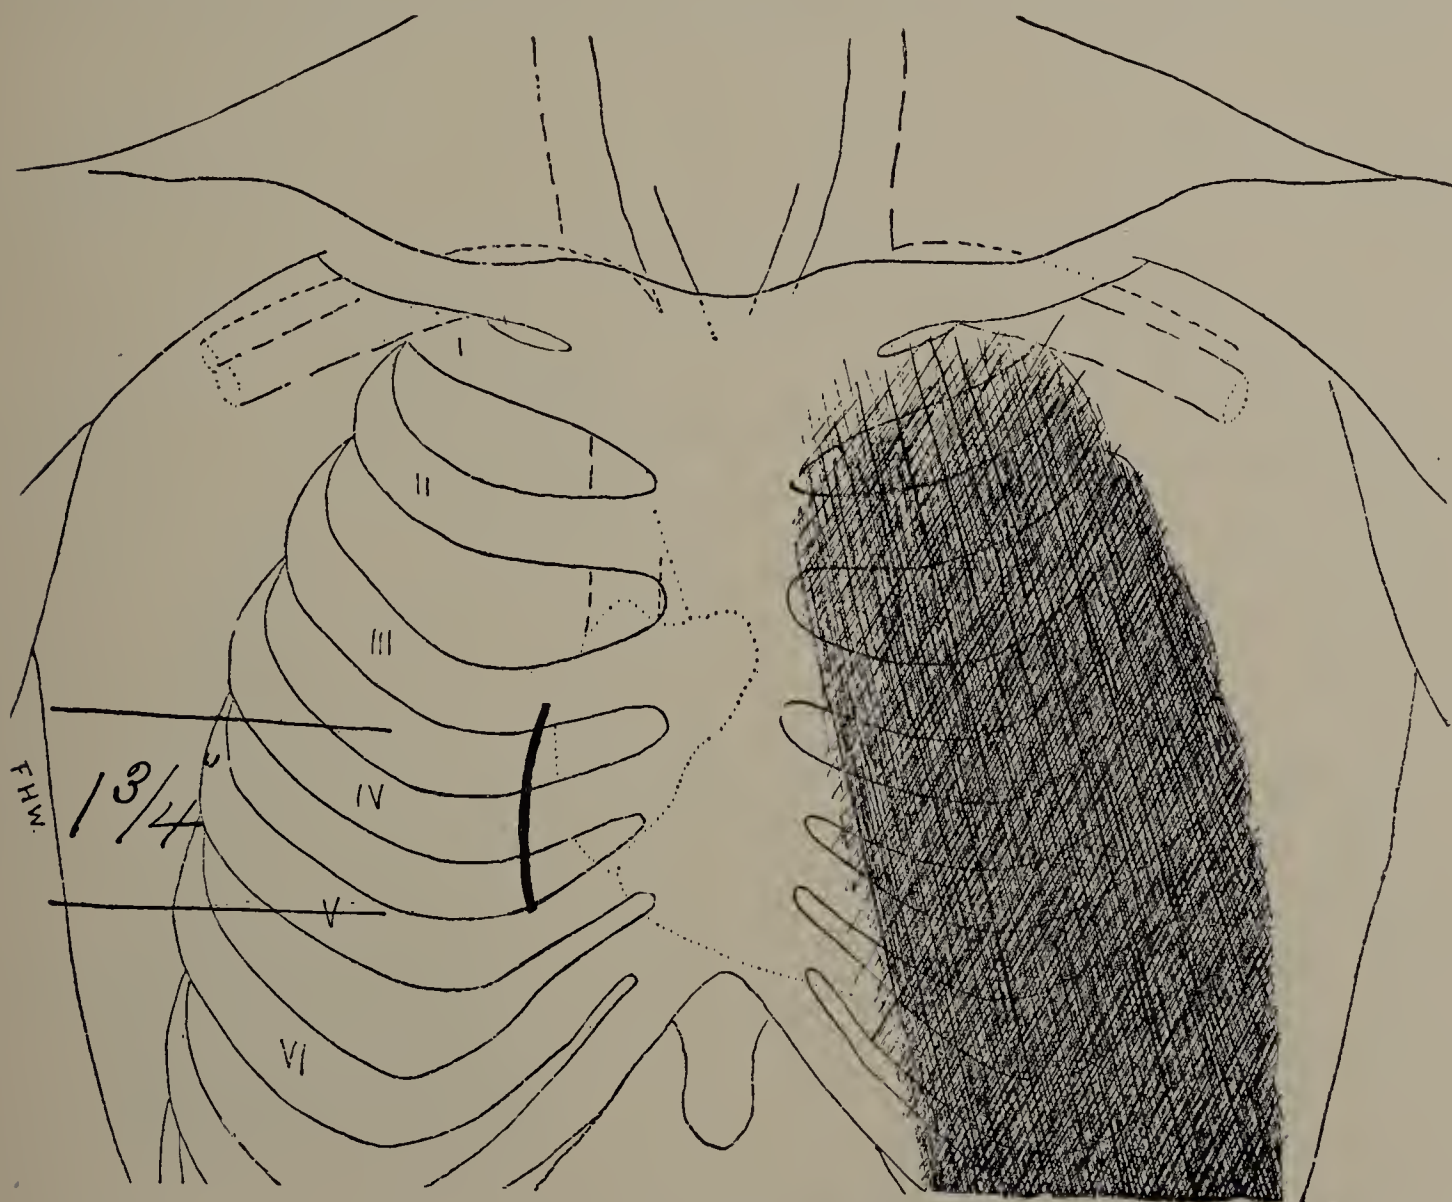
Mary F. April 10, 1897. First X-ray examination with screen. Pleurisy with effusion on left side; heart displaced to right. Excursion of diaphragm 4.5 centimetres, shortened on right side. (Cut one-third life size.)
